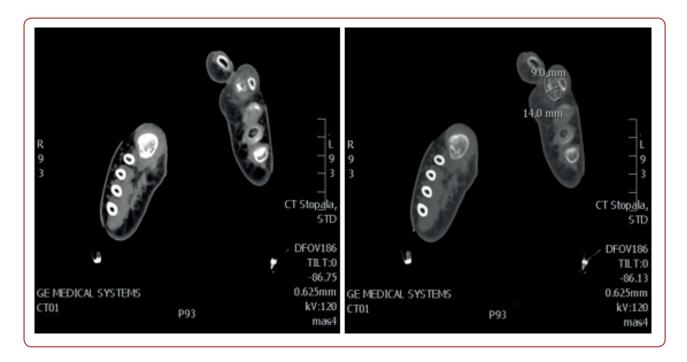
Computed tomography (CT) scan of the feet showing partially calcified soft tissue mass size 9.0 mm x 14.0 mm
